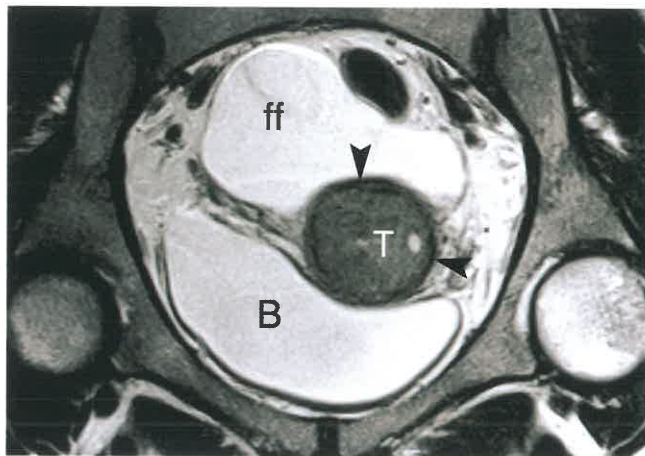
Cervical Carcinoma—MR. This T2-weighted MR image was obtained in an oblique coronal plane in order to image the cervix in transverse orientation. The tumor (T) appearing dark gray has nearly completely replaced the normal cervix seen only as a black rim (arrowheads). No parametrial invasion is evident. Free intraperitoneal fluid (ff) is seen in the cul-de-sac. B, bladder.
